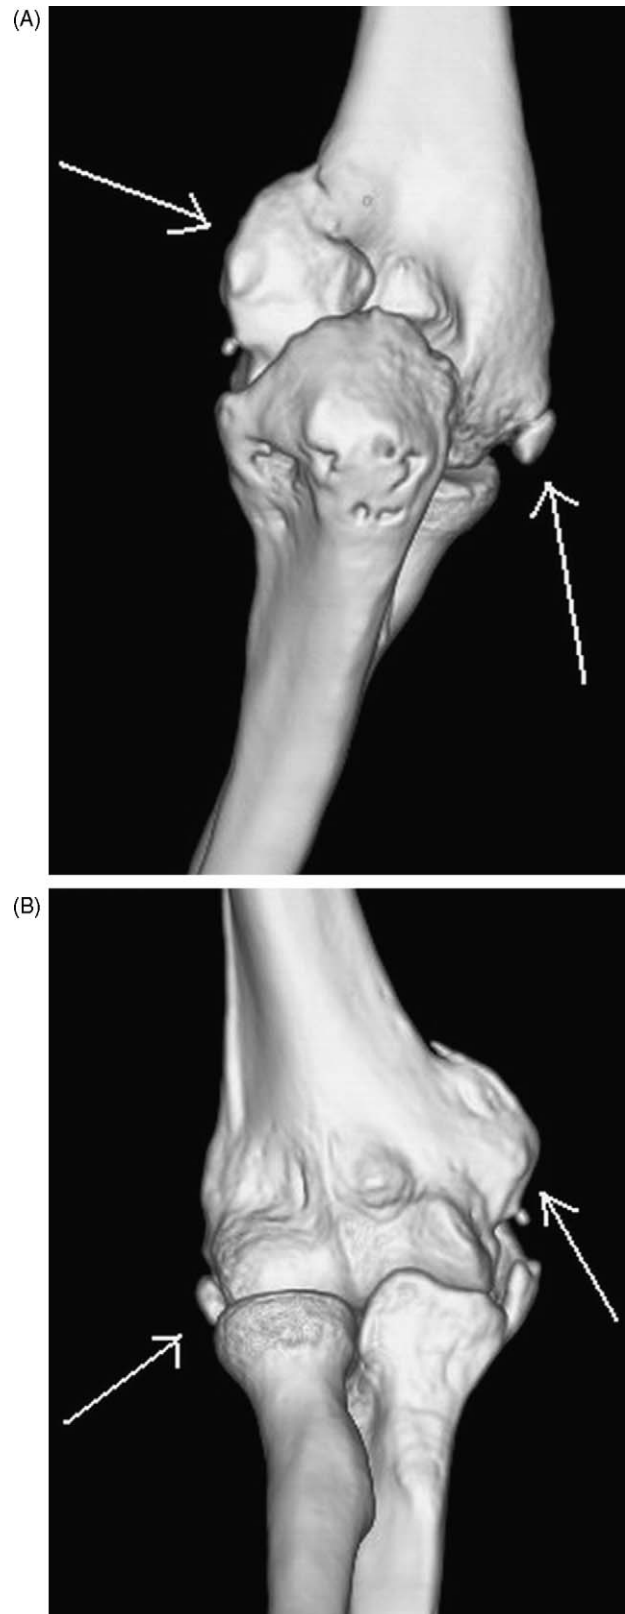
(A) Pre-operative 3-D CT posterior and anterior (P-A) view of the left elbow of the 4th case. HO was noted at the lateral and medial side of elbow. The medial HO separated from the medial humeral epicondyle. The lateral HO extends from humerus to olecranon. (B) Pre-operative 3-D CT A-P view of the left elbow of the 4th case.
